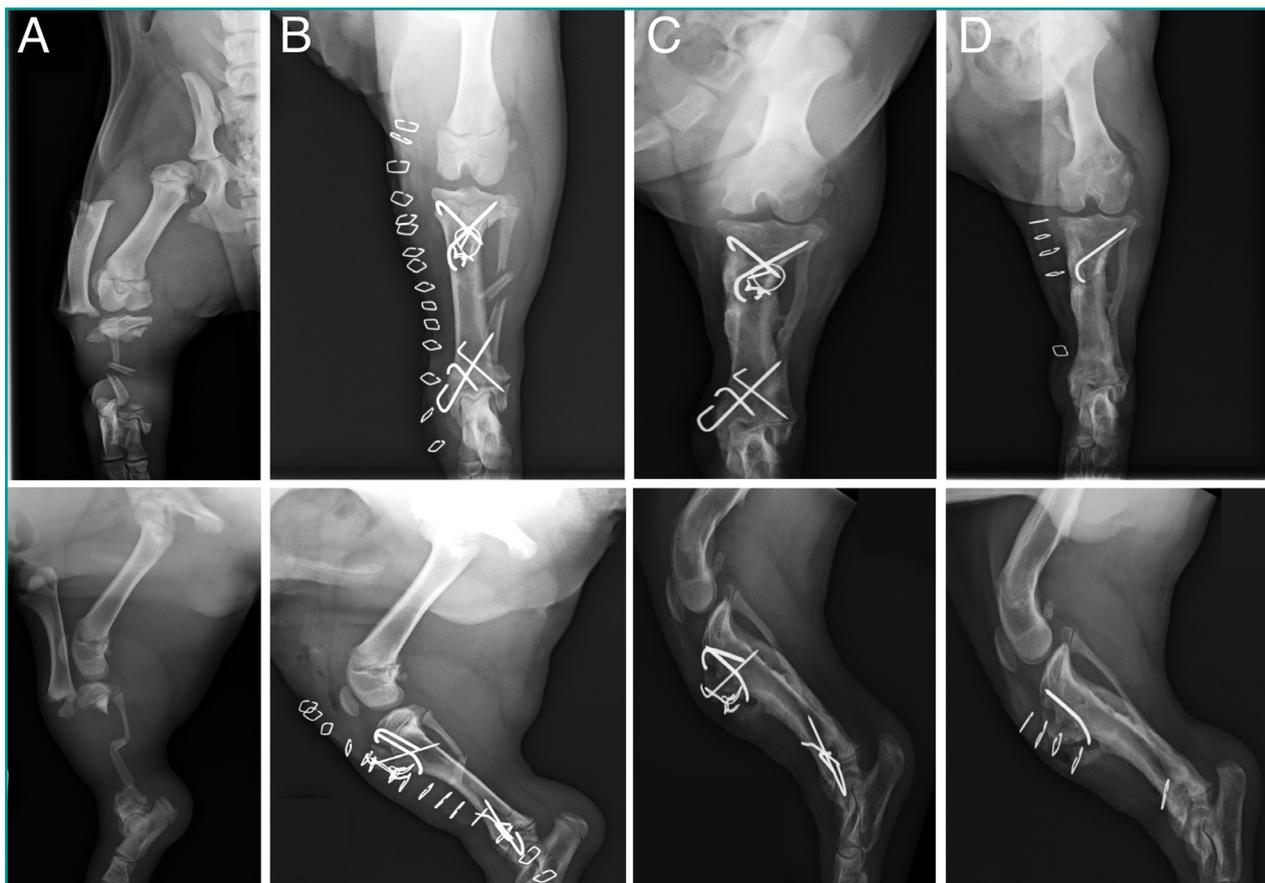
Perpendicular X-rays (A) prior to surgery, (B) after surgery, (C) at 20 days and (D) following removal of the implant, at 30 days. (A) The preoperative X-rays show severe, proximal, lateral dislocation of the right tibial shaft associated with fractures of the proximal and distal parts of the tibia. Fractures of the tibial tuberosity, fibula, distal physes of the femur and subluxation of the femoral head can also be seen. (B) The postoperative images show the reduction of the tibial shaft with good frontal and sagittal alignment. (C) This X-ray documents bone healing at 20 days. (D) Removal of the implanted fixation devices 30 days after surgery: a proximal nail was left in situ because it had become incorporated in the periosteal callus.
